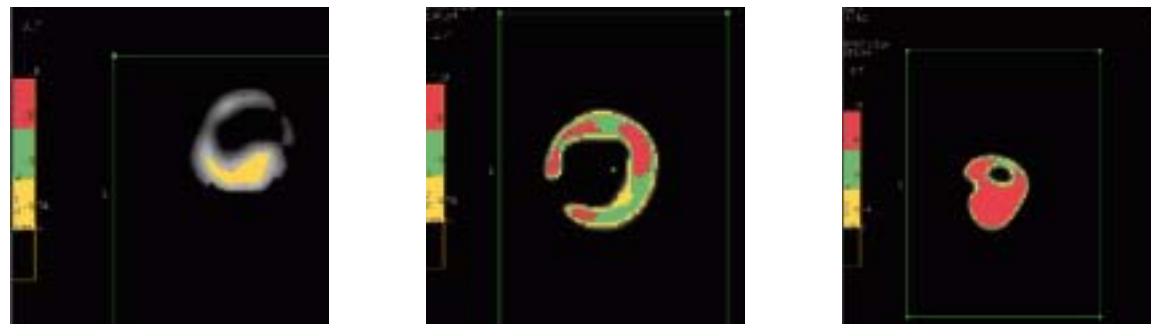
CT reconstructions with dedicated carotid artery plaque assessment algorithms for densitometric characterization.
